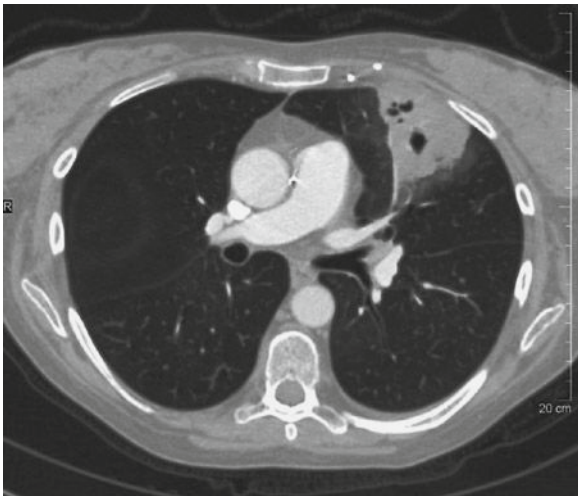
CT scan of the chest showing a wedge shaped infiltrate in the left upper lobe with cavitation in a patient with GVHD on immunosuppressive therapy following HSCT who developed nocardia pneumonia
